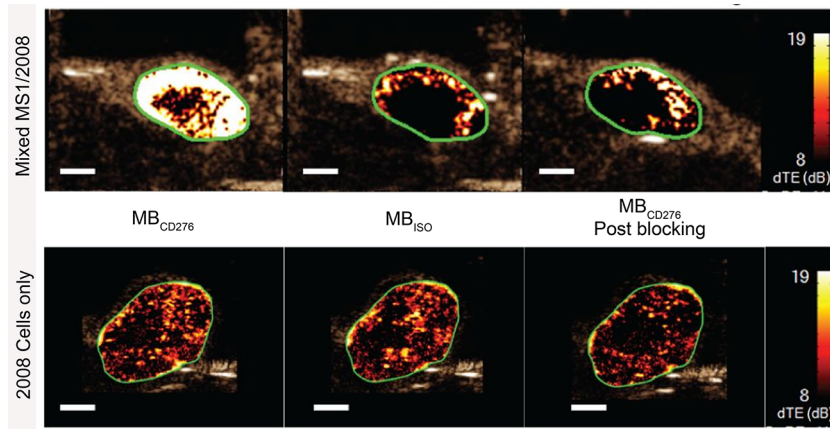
Preclinical contrast-enhanced ultrasound imaging of angiogenesis.
